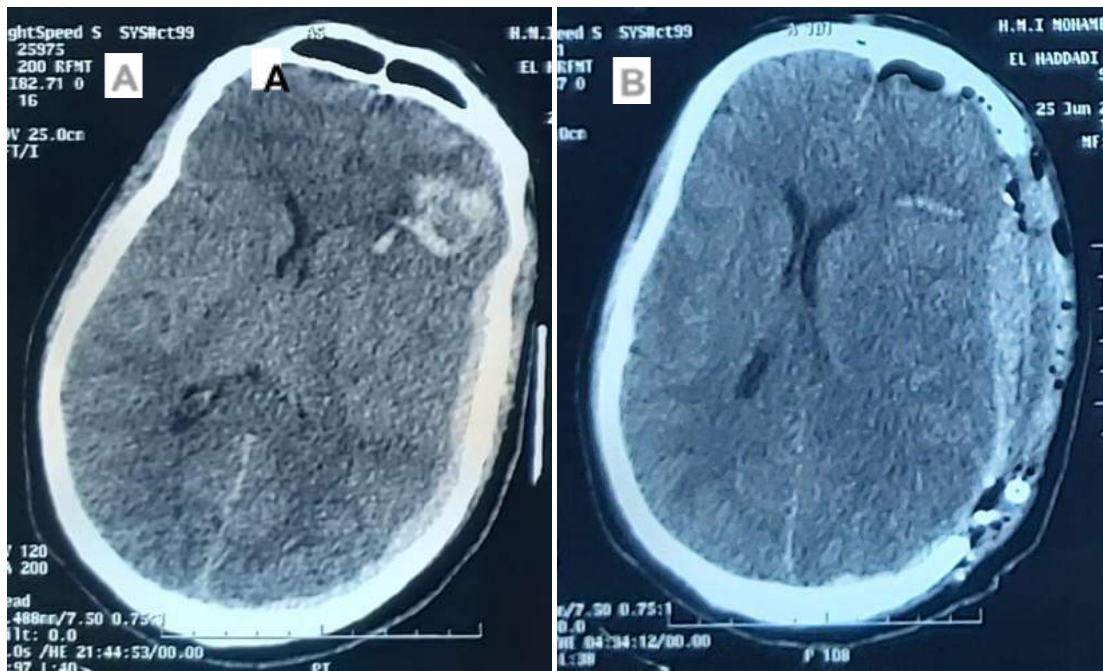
A/ Head CT shows a spontaneous hyperdense ASDH of 12mm thickness on the left hemisphere with 8mm midline shift. Diffuse brain edema. B/ Postoperative axial head CT-Scan after decompressive craniotomy and evacuation of the ASDH and also the ICH.
